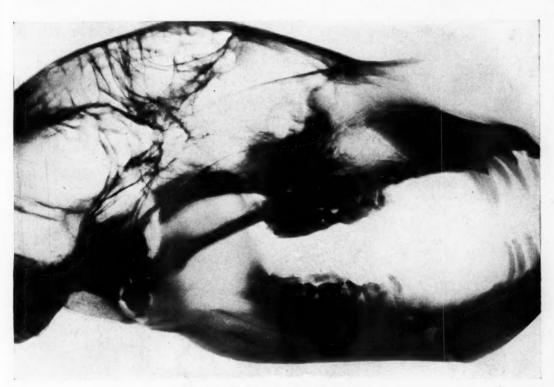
Radiograph of teeth of bear.
